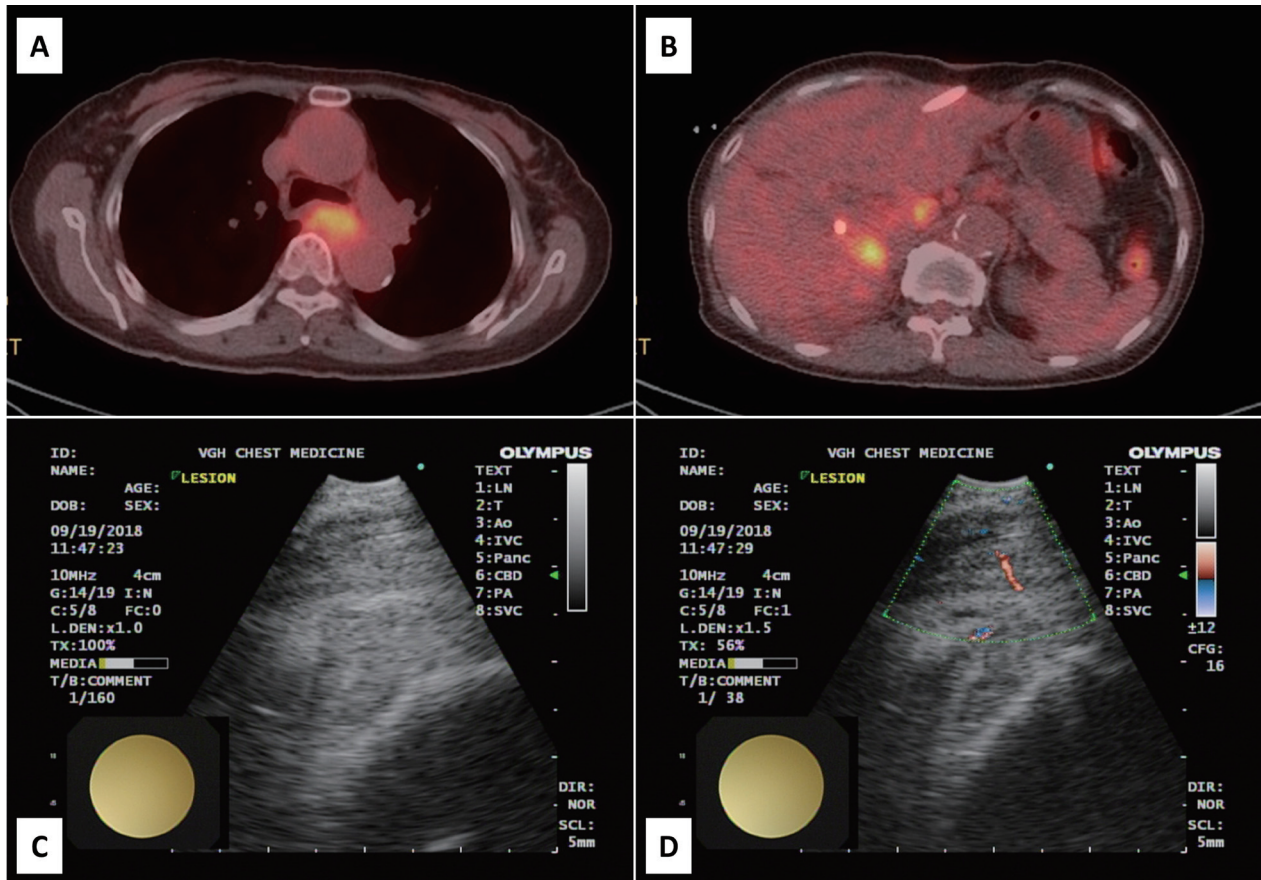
F-18 FDG whole-body positron emission tomography/computed tomography imaging of endobronchial ultrasound and endobronchial ultrasound-guided transbronchial biopsy.
